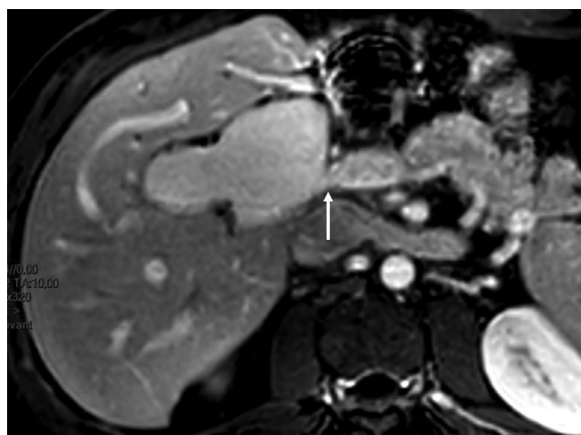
T1 magnetic resonance imaging sequence after gadolinium injection, showing the aneurysmal dilation of the upper-anastomotic portal vein. Notice the presence of local stenosis of the portal anastomosis (arrow).
